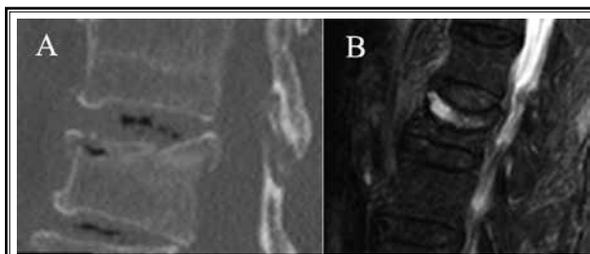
Fracture cleft morphology. Small gas-containing cleft within T12 on sagittal CT (A), and large fluid filled cleft within L1 on sagittal STIR MR (B).
